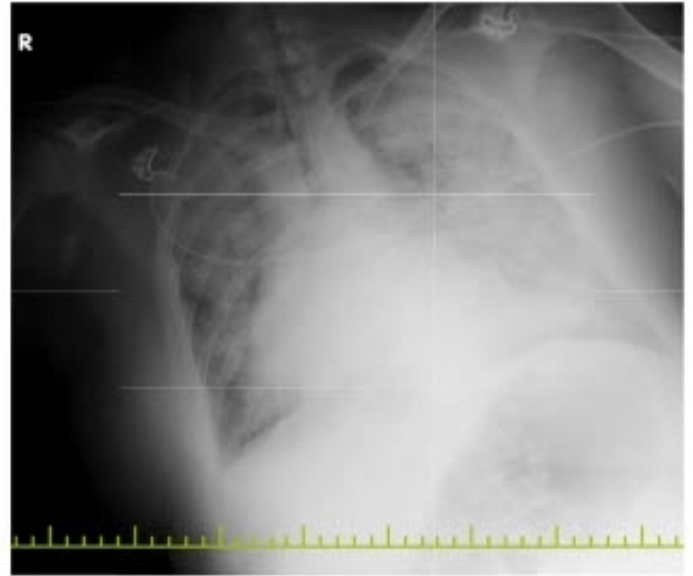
Posterior Anterior Chest Radiograph before Hemodialysis
